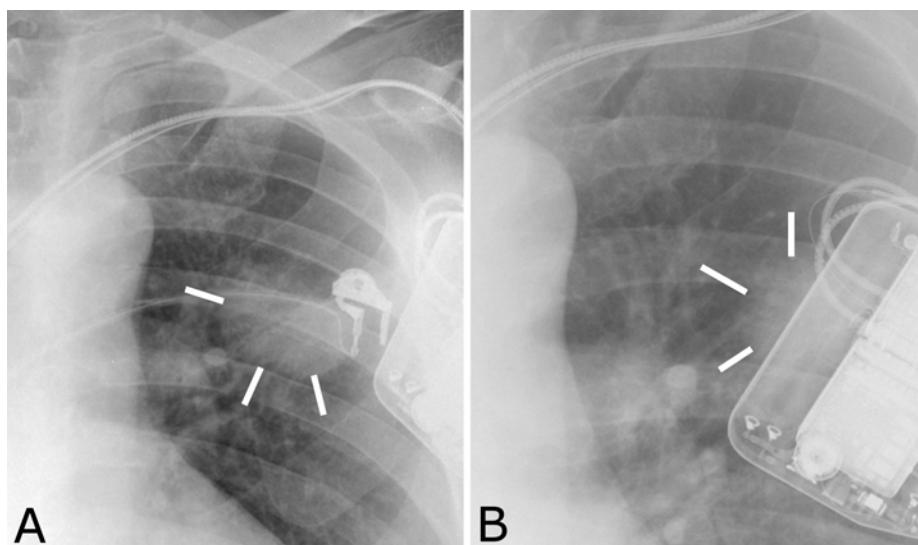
Pulmonary nodule over time. This nodule was located just below the implanted control pack for the patient's transvenous cardiac pacer (a rather unfortunate place to have a nodule). A. Frontal chest radiograph where the nodule was identified. B. Prior study from over three years previous from another institution where the nodule had not been seen, but fortunately proved to be unchanged.
